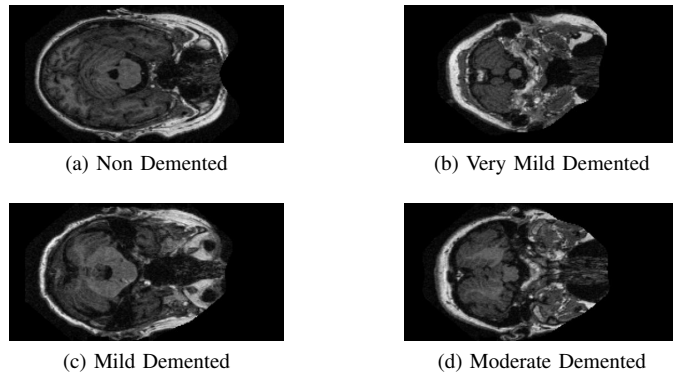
Sample MRI Brain Scans from the Alzheimer's Disease Dataset
